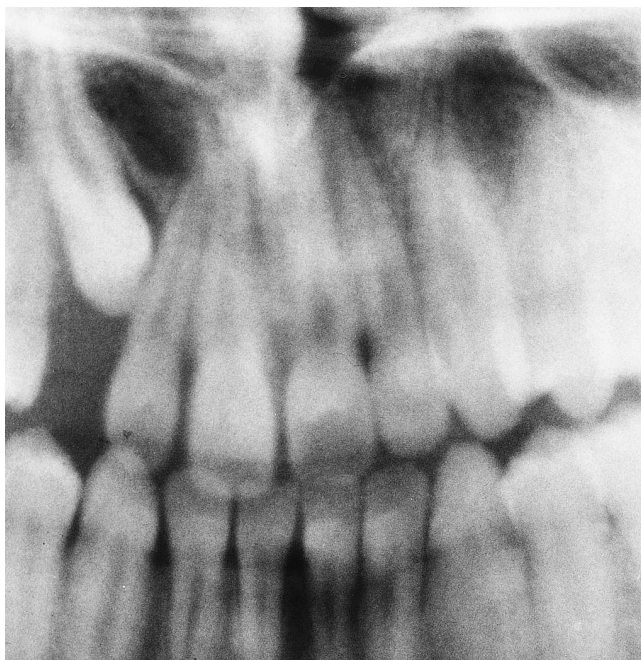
Sectional orthopantomogram at age 14 years 1 month.
